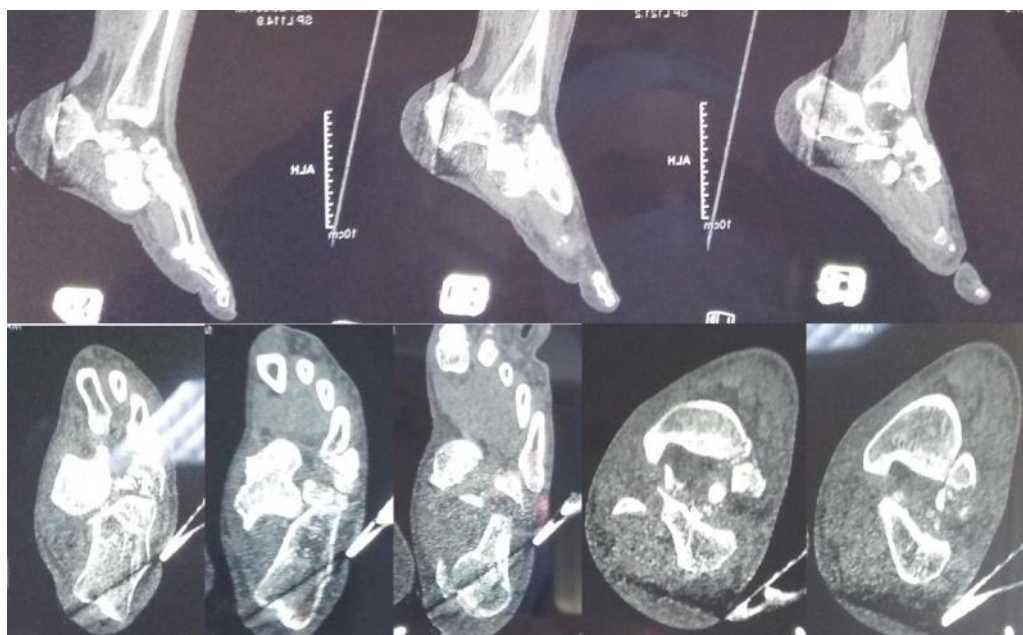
CT-scan was performed showing the medial, anterior and caudal displacement of the talus without an associated talar fracture.
